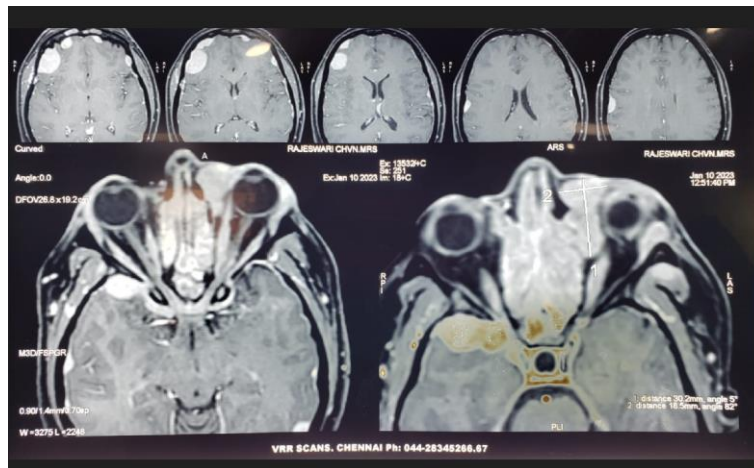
MRI showing homogenous enhancing soft tissue lesions in nasal cavity, paranasal sinuses and dura
